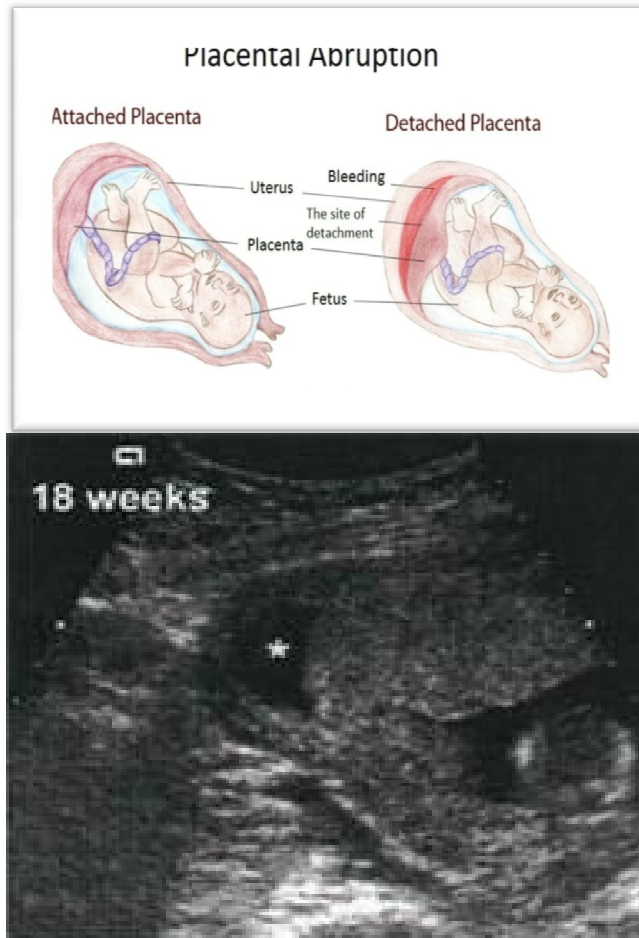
Placental abruption: Sonogram of the placenta shows a cystic area behind the placenta (*) which is the Retroplacental Hematoma. (*Burwin Institute Notes*)
